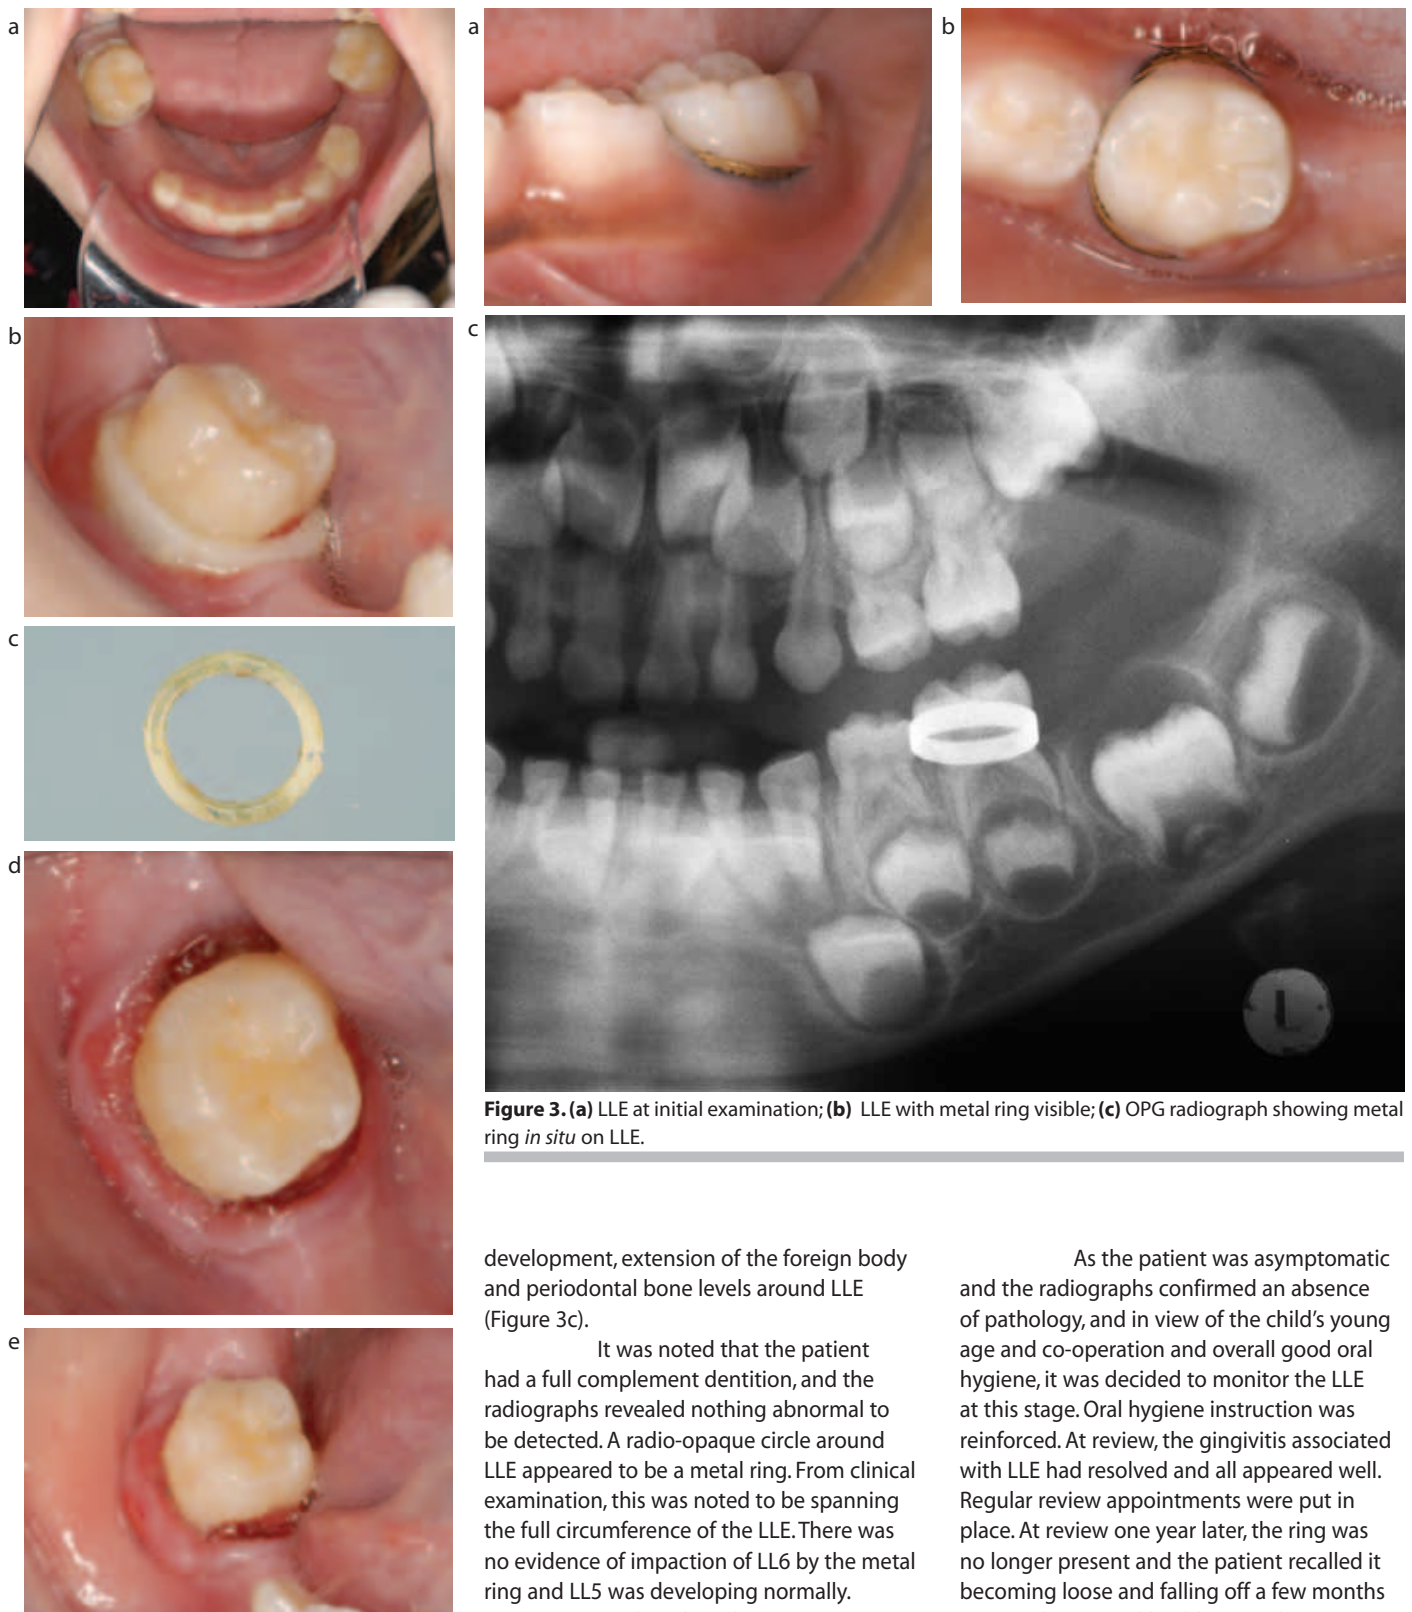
(a) LLE at initial examination; (b) LLE with metal ring visible; (c) OPG radiograph showing metal ring *in situ* on LLE.
